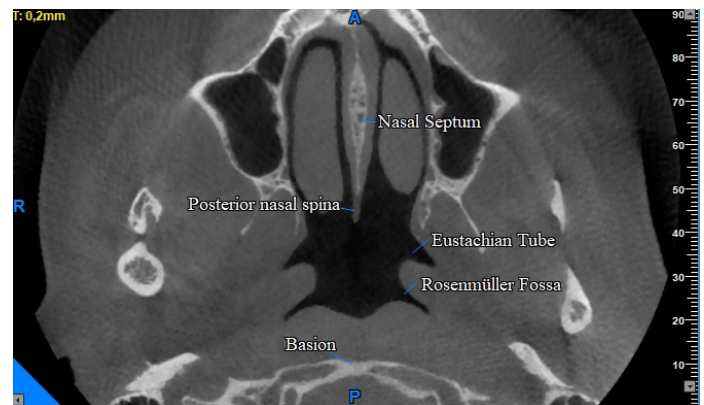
Anatomical structures of the nasopharynx in CBCT axial sections. Position of reference points (Posterior nasal spina and basion), Eustachian tube orifice, and Rosenmüller fossa
